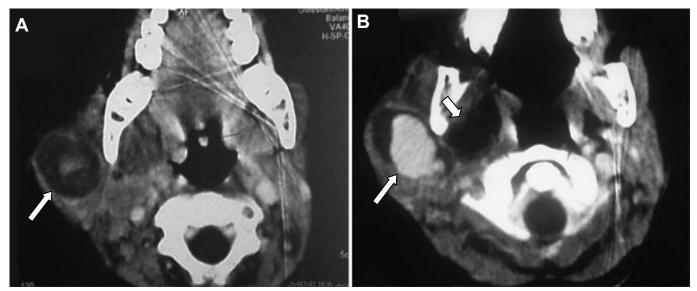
A and B. Axial view contrast-enhanced CT scan of the neck of a 5-year-old girl. There is a soft tissue density lateral to the right mandibular ramus (35×25 mm) large central enhancement (arterial phase) which suggests pseudoaneurysm (thin arrow). Also there is another soft tissue medial to the right mandibular ramus without enhancement which suggests hematoma (thick arrow).
